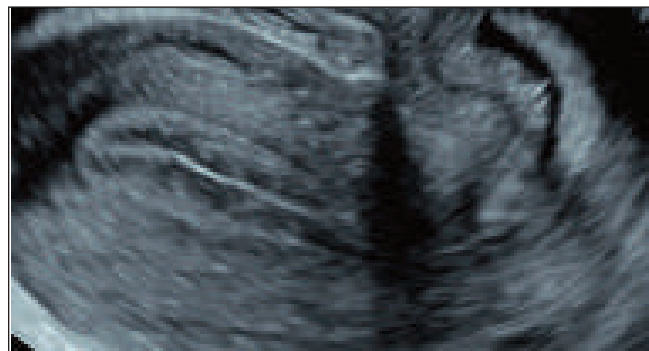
mid sagittal plane of the uterus on 2D ultrasound with arrow heads pointing towards thin hypoechoic line outside the endometrium-myometrial junction.
